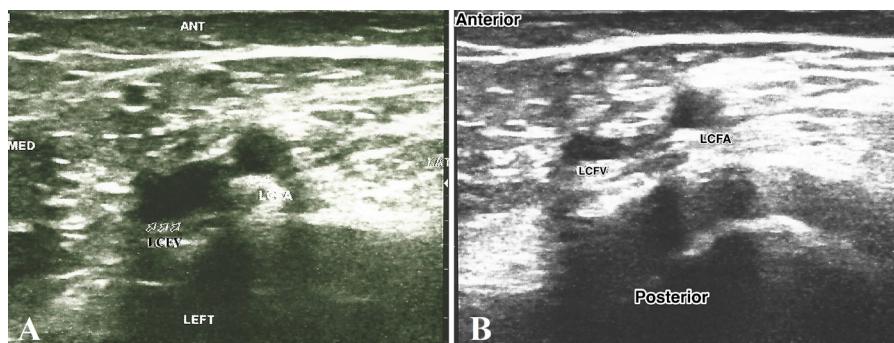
Ultrasonographic image of the femoral vein and artery on the transverse plane with and without compression. A: without compression. Femoral vein lies on the medial side of the common femoral artery. B: with compression. Notice how the vein response to the compression.
